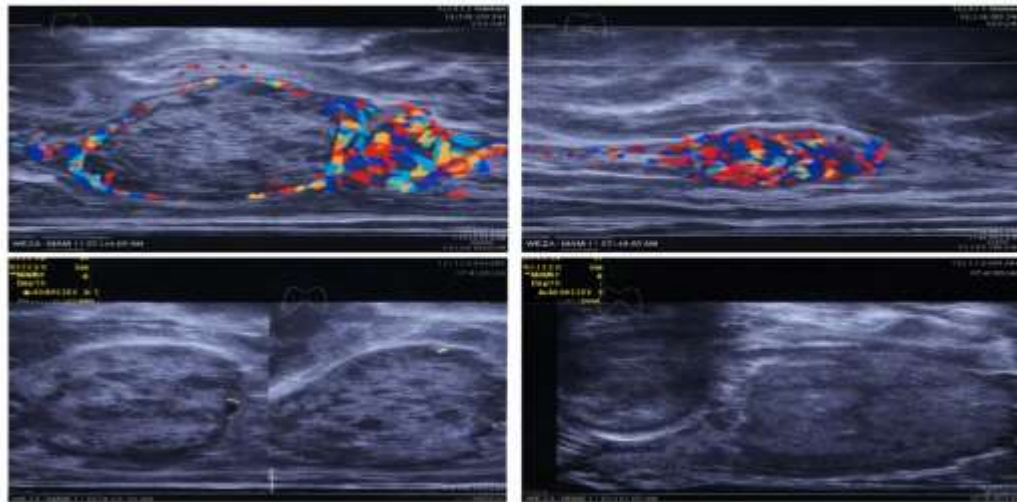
Thyroid ultrasound with color Doppler : revealed a heterogeneous and markedly hypervascularized thyroid gland , associated with a nodular lesion in the inferior pole of the right lobe , consistent with nodular Graves disease
